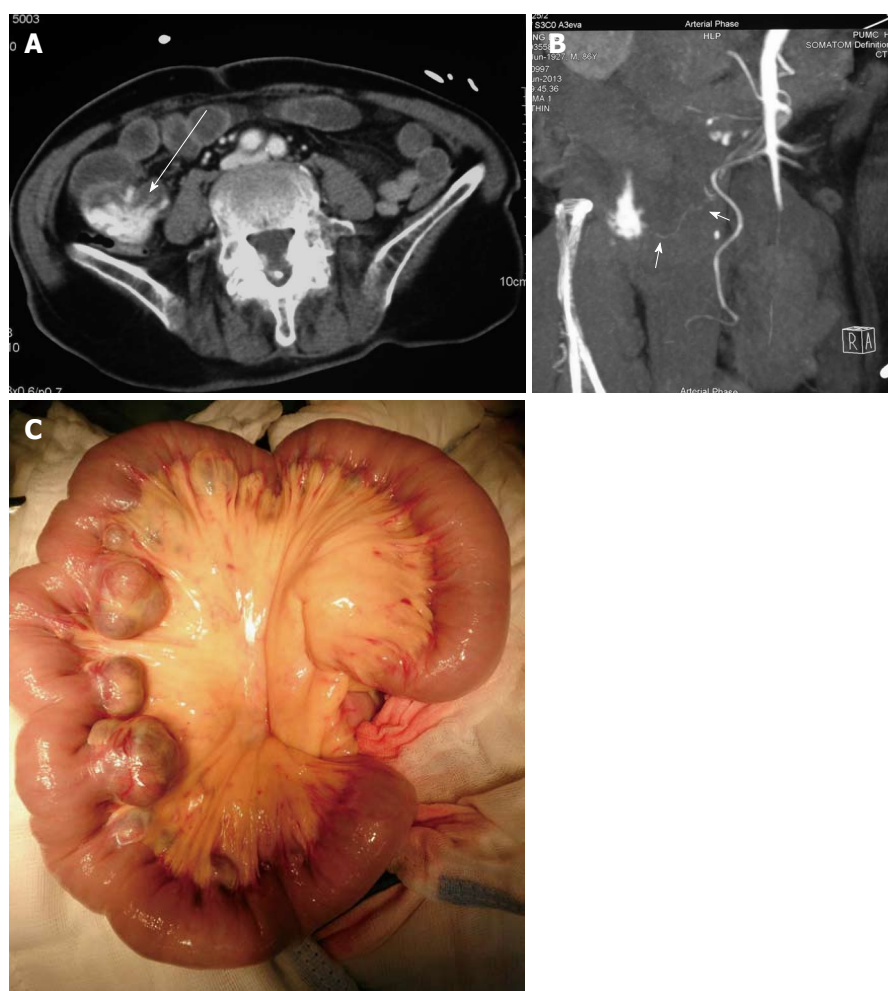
Imaging of case 1. A: Computed tomography (CT) angiography revealed contrast extravasation in a jejunal diverticulum (arrow); B: CT angiography showed the blood supply for the jejunal diverticulum source was from a branch of the superior mesenteric artery (arrow); C: Multiple diverticula in a 30 cm segment of the jejunum.
